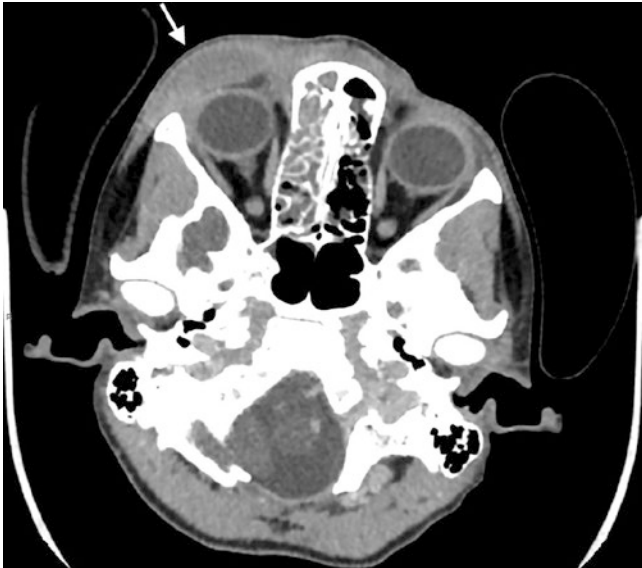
Right periorbital cellulitis. Axial contrast-enhanced CT image demonstrates swelling of the right orbital preseptal soft tissues
